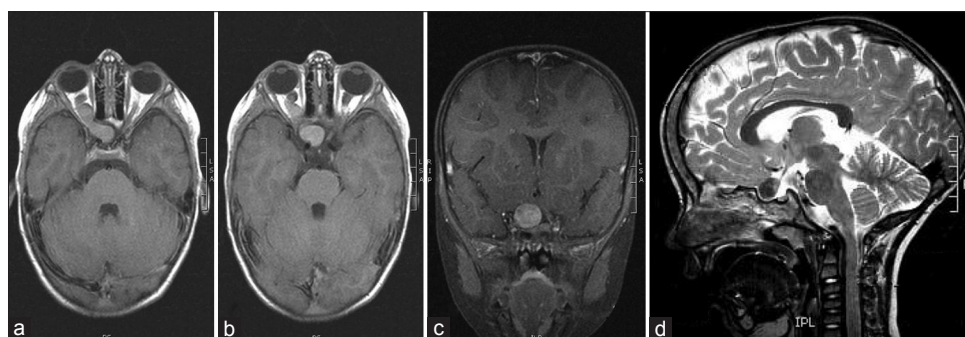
(a, b) Preoperative T1 magnetic resonance (MR) images demonstrates expansive changed and elongated right optic nerve. (c) Preoperative coronal plane T1 gadolinium-enhanced MR image. (d) Preoperative sagittal plane T2 MR image
